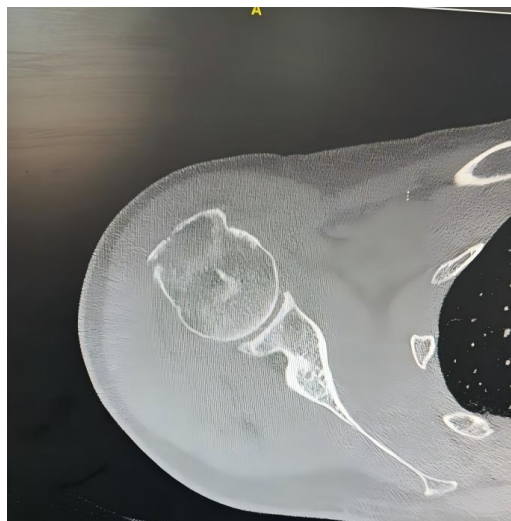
Post-reduction control CT SCAN
